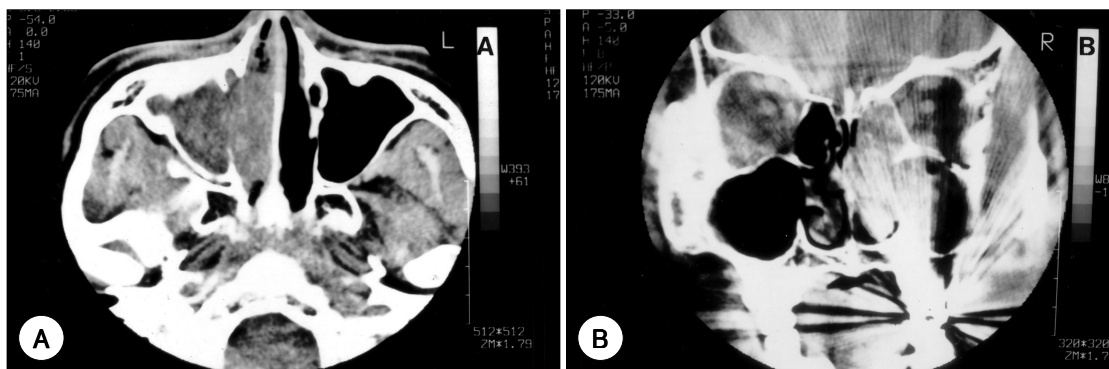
Axial (A) and coronal (B) CT showing an increased density mass lesion at right side nasal cavity and destructive change of middle and inferior turbinate and medial wall of maxillary sinus.
